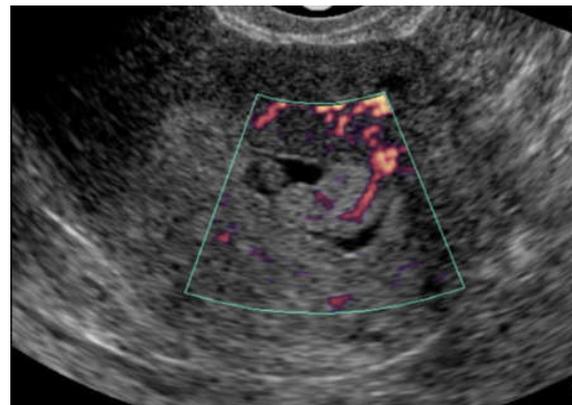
Power Doppler showing vascularity in the pedicle of polyp
